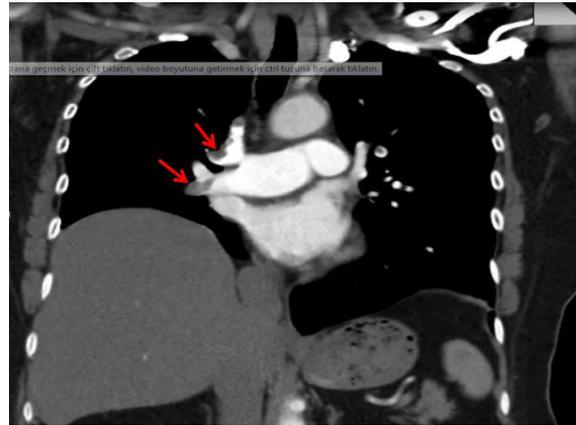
Computed tomography pulmonary angiography showing filling defects in the bilateral main pulmonary arteries consistent with acute bilateral pulmonary embolism (red arrows).
